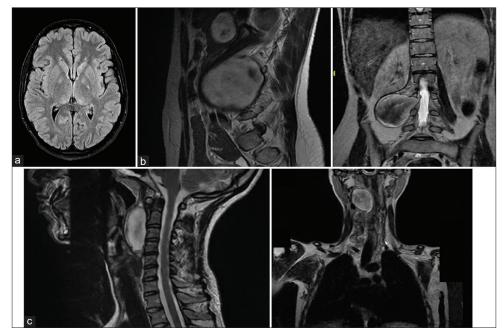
(a) Axial cut of magnetic resonance imaging (MRI) brain (fluid-attenuated inversion recovery) showing bilateral hamartoma in globus pallidus. (b) Preoperative sagittal and coronal cut MRI T2 of lumbar spine showing an ill-defined mass at the level of L3–5. (c) Preoperative sagittal and coronal cut MRI T2 of the cervical spine showing a predominantly hypodense well-defined mass found in the right retropharyngeal space.
